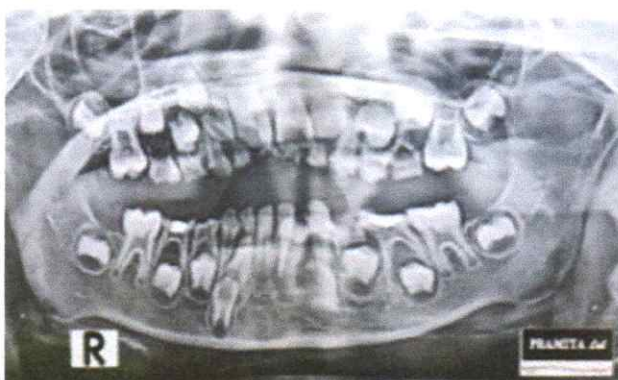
Panoramic radiograph at initial examination revealing 51 and 61 gangrene radix.
